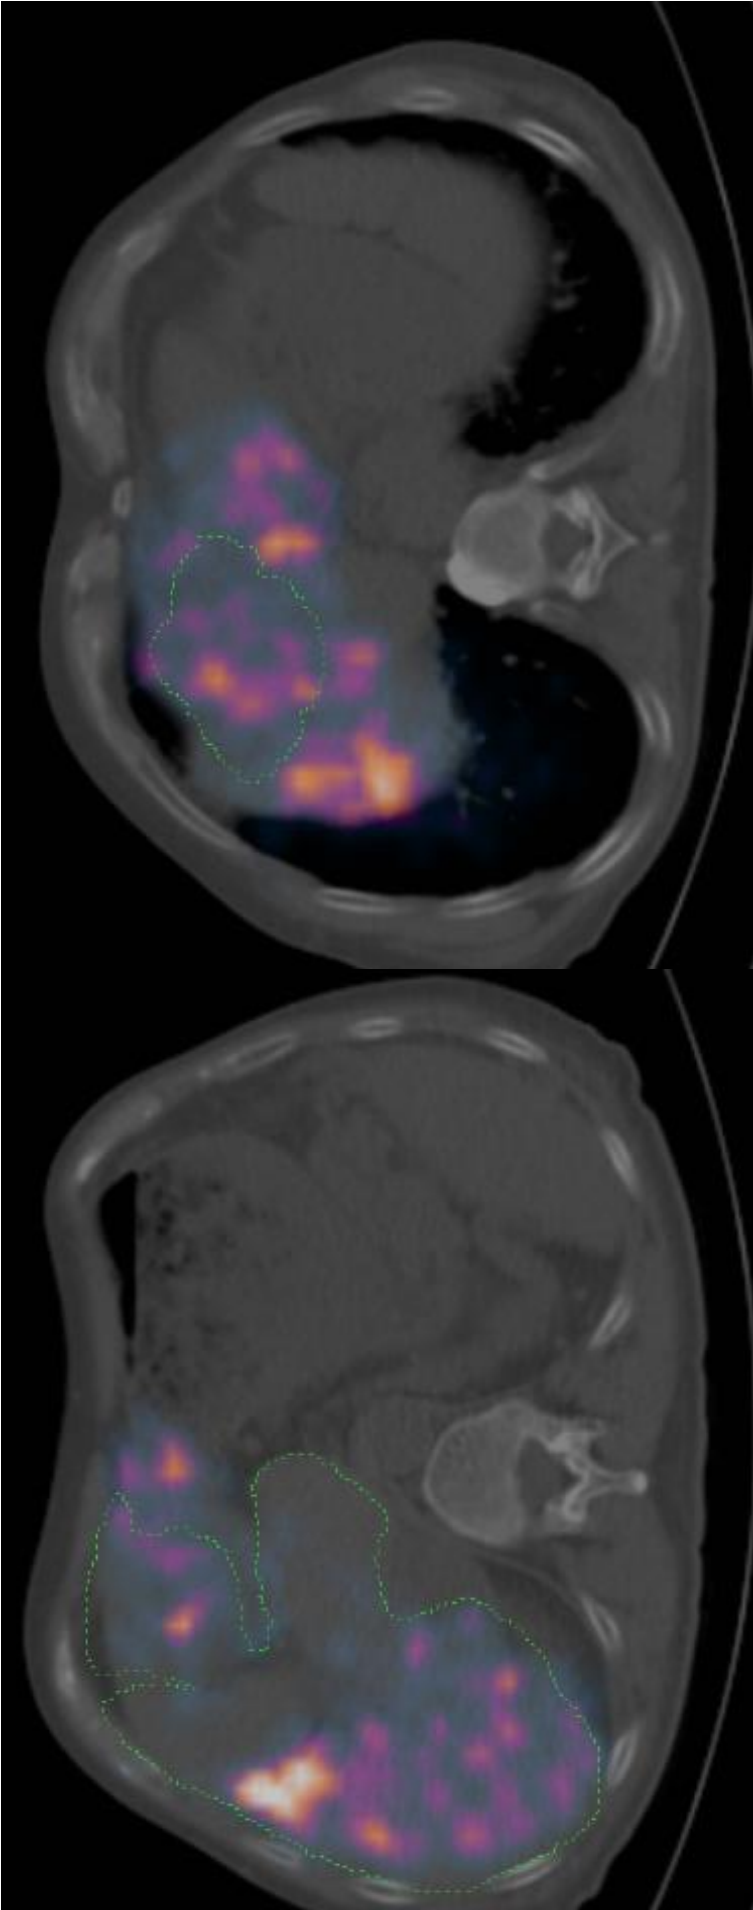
The liver segmented on the diagnostic CT (green lines) projected over the low-dose CT after registration of the two scans for two transversal slices (left and right). Larger differences between the two livers are observed closer to the diaphragm.
